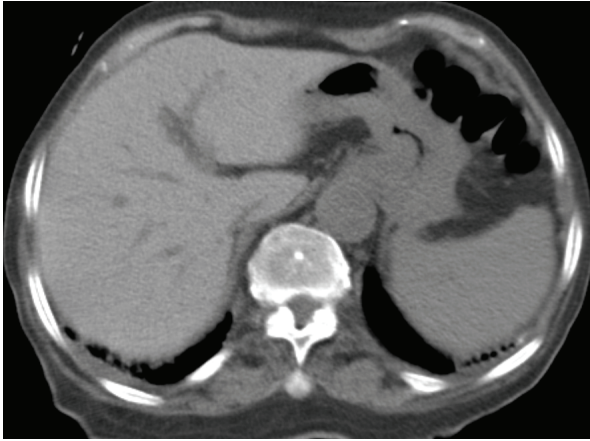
Non-contrast CT showing high attenuation of the liver
